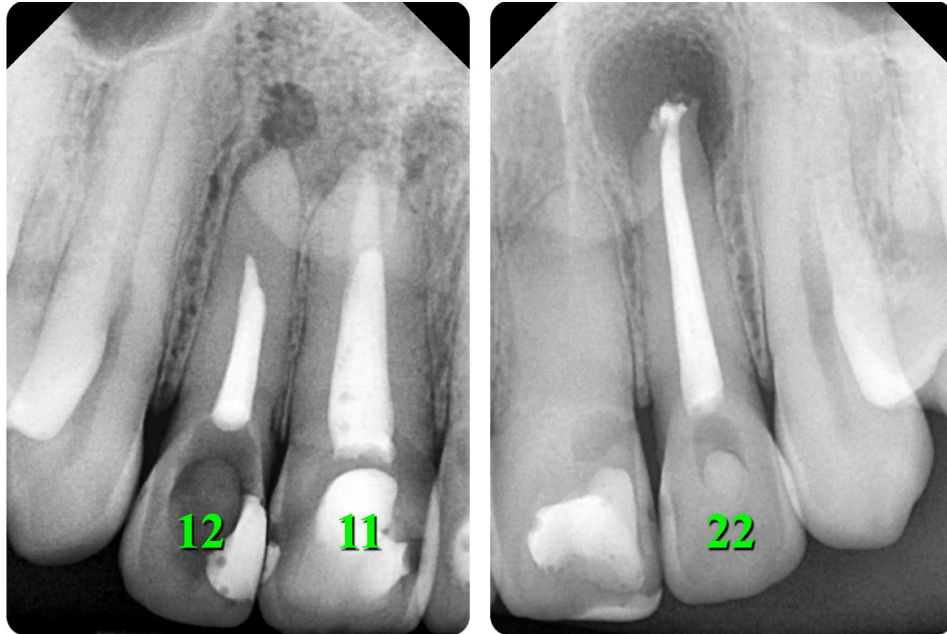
Preoperative radiographs of a 31-year-old female who was referred for endodontic microsurgery of the teeth 12, 11, and 22. 12, upper right lateral incisor; 11, upper right central incisor; 22, upper left lateral incisor.
